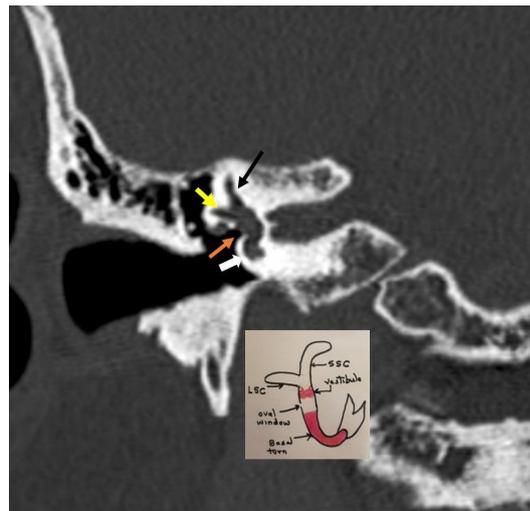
Coronal image of high resolution CT (HRCT) temporal bone on the right side depicting the Headless Mermaid in ballerina pose—basal turn of the cochlea with promontory (solid white arrow); superior semicircular canals (SCC) and lateral semicircular canals (LCC) (black thin arrow and yellow arrow, respectively); umbilicus (orange arrow). Transparency drawn by Dr Anagha Joshi.
